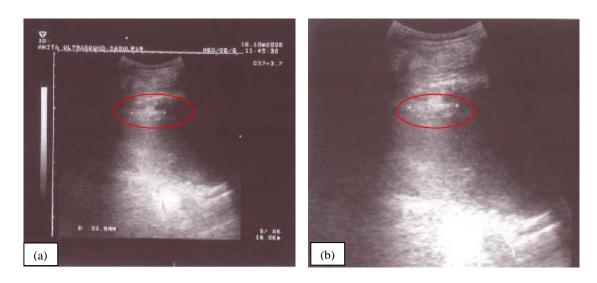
Ultrasonic image of tablet formulation retained in human stomach 30 min post peroral administration
